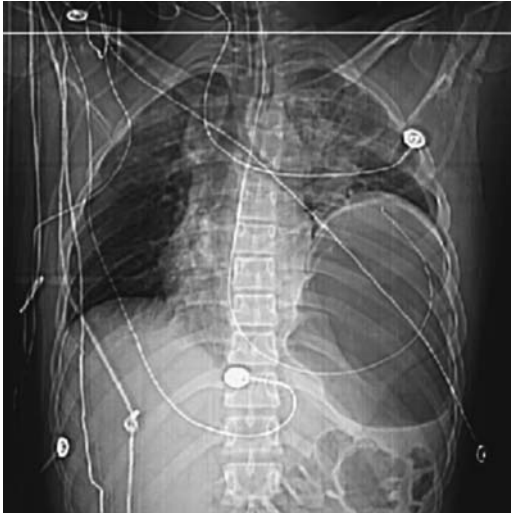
Traumatic rupture of left hemidiaphragm. A scout view localizer prior to computed tomography (CT) reveals mediastinal shift to the right, partial left lung atelectasis and an elevated stomach. (Courtesy of Patrick Fultz, M.D., University of Rochester.)
